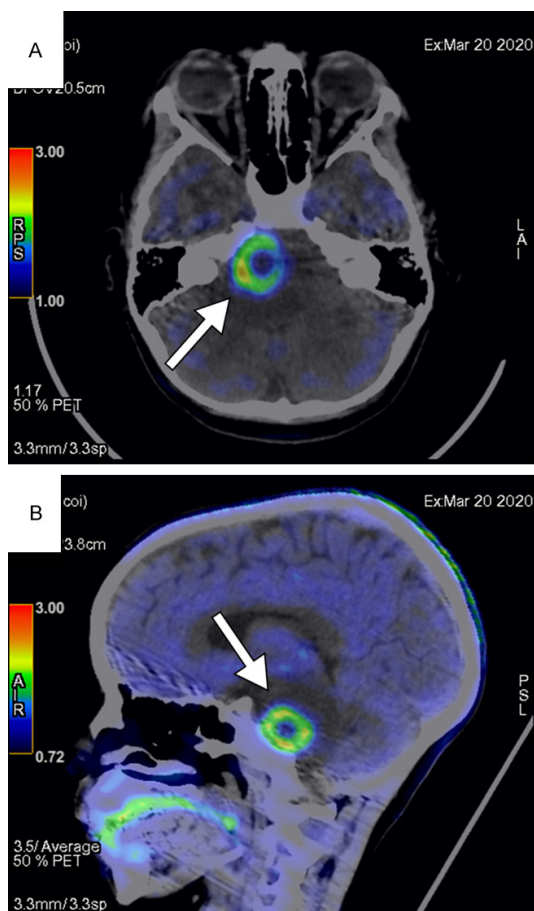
Medulloblastoma recurrence after systemic chemotherapy and radiotherapy. Axial (A) and sagittal (B) ^{18}F -DOPA PET/CT images show ring DOPA uptake in the brainstem (arrow).
